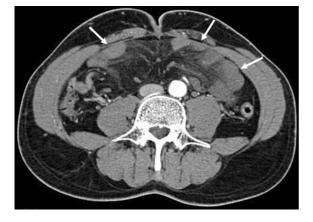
Axial multidetector-row CT image of a patient with surgically proven small bowel venous ischemia, showing haziness of the mesentery which is tributary of the ischemic bowel loops (*arrows*)
